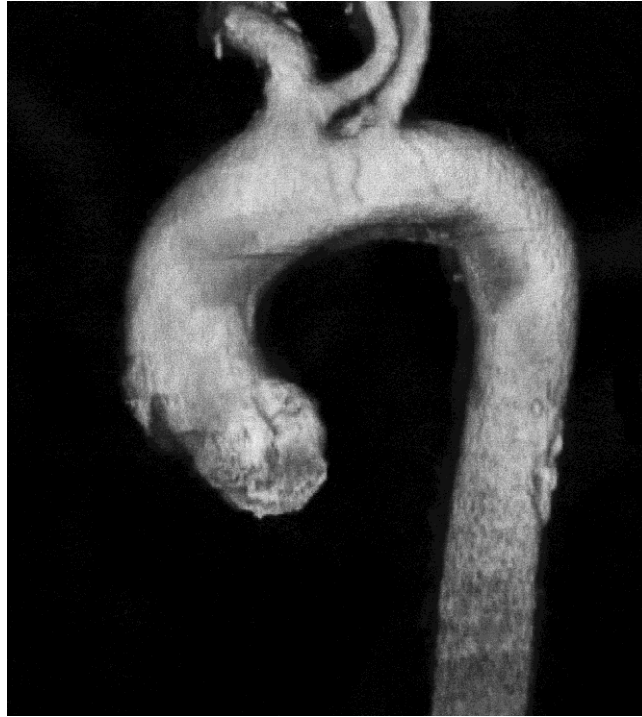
Angio-CT showing only two branches arising from the aortic arch. From left to right: the BCT and the LSA. The LCCA was observed arising from the BCT.
